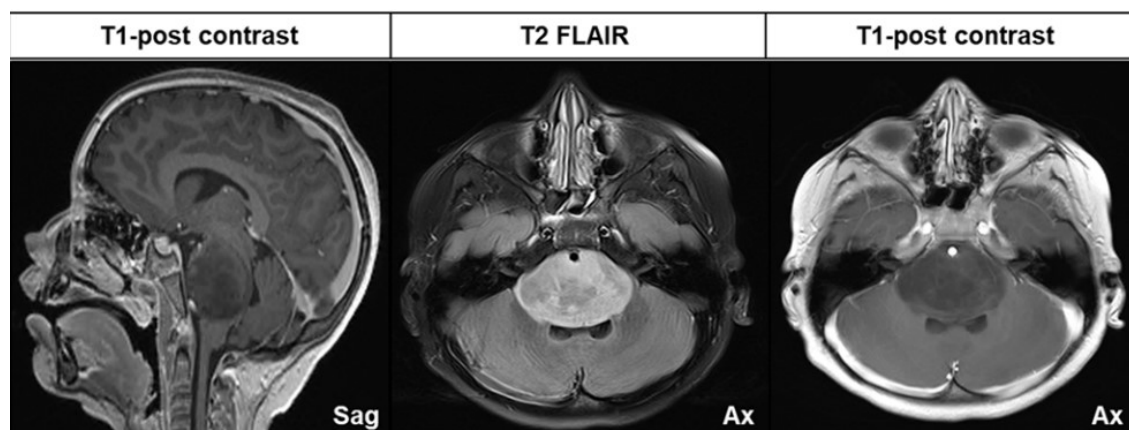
MRI images of a DIPG patient, showing hypointense T1 and hyperintense T2 contrast. Image obtained from Chiang J. *et al.*, 2020.
